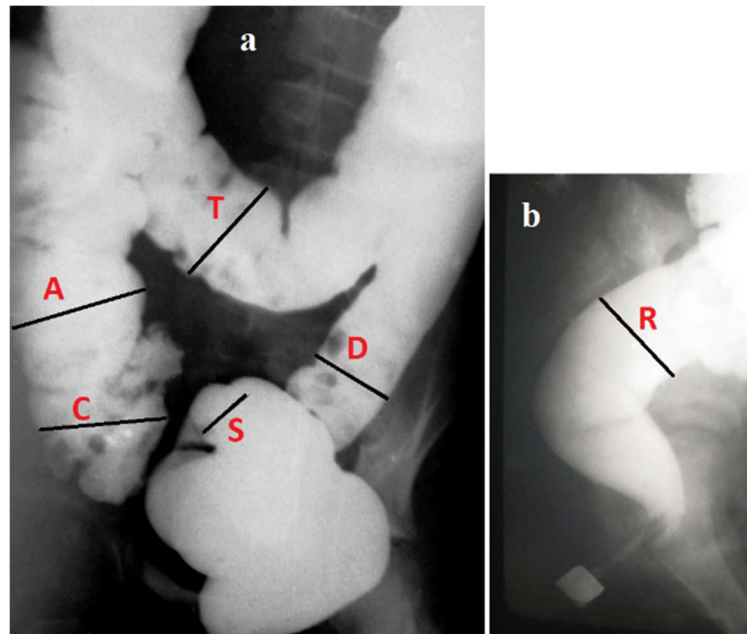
(a). The frontal radiograph shows the measurement sites: c - caecum, a - ascending colon, t - transverse colon, d - descending colon, s - sigmoid colon. (b). On a lateral radiograph, the measurement location for the descending branch of the rectum is shown as (R). The length of the anal canal is measured between the rectum and a radiopaque marker located near the anus.
